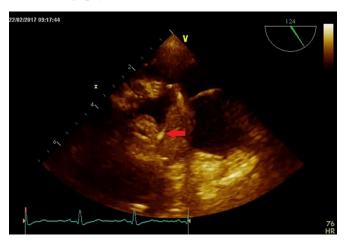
Transthoracic echocardiography – large vegetation 30  $\times$ 17 mm attached to the pacemaker leads.
